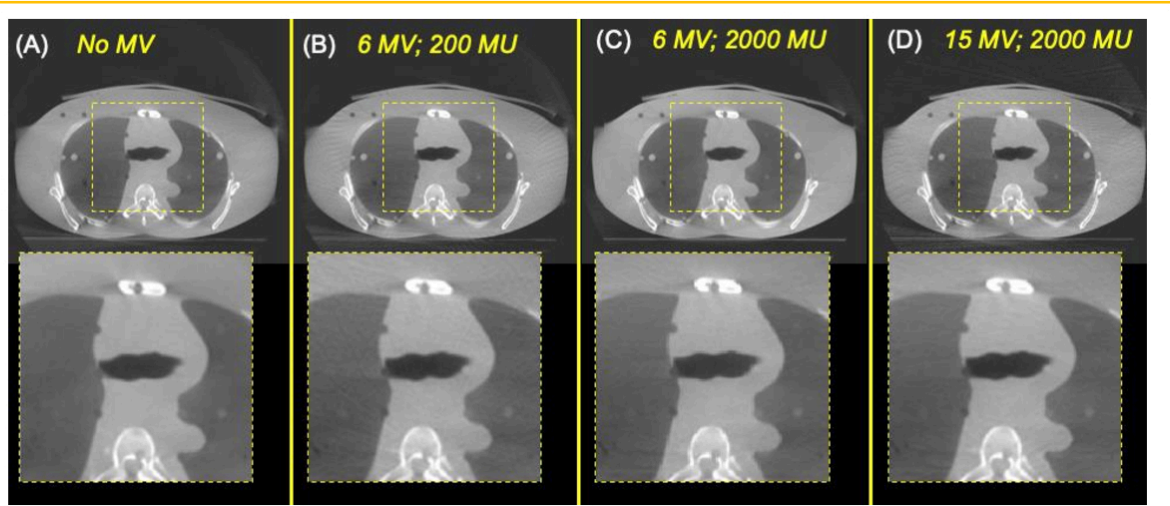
Axial slices at the carina level of the CBCT reconstructions without any treatment beam (a), with 200 MU of 6 MV (b), with 2000 MU of 6 MV (c), and 2000 MU of 15 MV fields (d) simultaneously treating.
